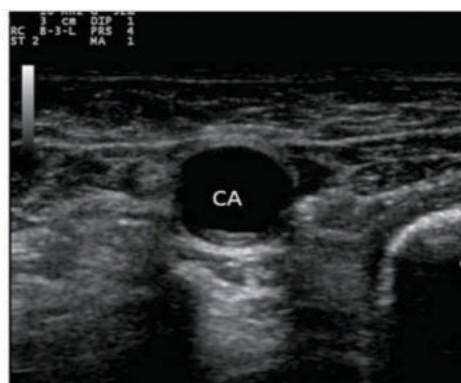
Ultrasound image of the right side of the neck showing absence of internal jugular vein. CA: Carotid artery
